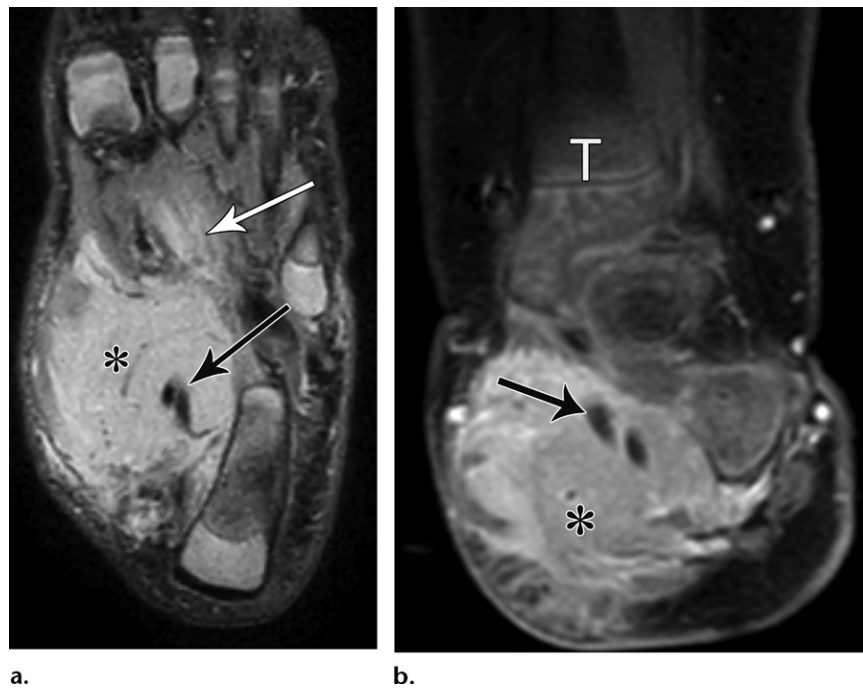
Congenital fibrosarcoma of the left foot in a 3-month-old girl. (a) Long-axis fat-suppressed T2-weighted image shows an irregular mass (*) with ill-defined margins involving the medial aspect of the foot, with invasion of the plantar muscles (white arrow). The mass has relatively homogeneous high signal intensity. The tibialis posterior and flexor hallucis longus tendons (black arrow) are encased by the mass. (b) Short-axis contrast-enhanced fat-suppressed T1-weighted image shows avid enhancement of the mass (*). Arrow = encased tendons, T = tibia.
